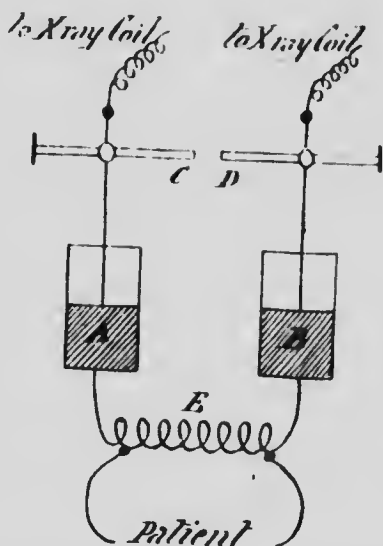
D'ARSONVAL HIGH-FREQUENCY APPARATUS. *A* and *B*, Leyden jars; *E*, small solenoid connected to outer coats of *A* and *B*; *C* and *D*, electrodes connected to inner coats of *A* and *B*, and to secondary terminals of X-ray coil.
